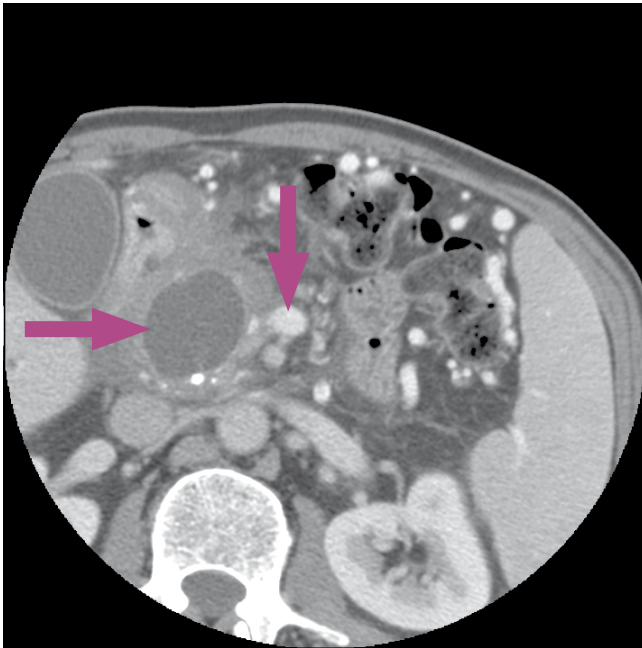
Computed tomography images reveal a large pancreatic pseudocyst (horizontal arrow) and associated gastroduodenal artery pseudoaneurysm (vertical arrow).
